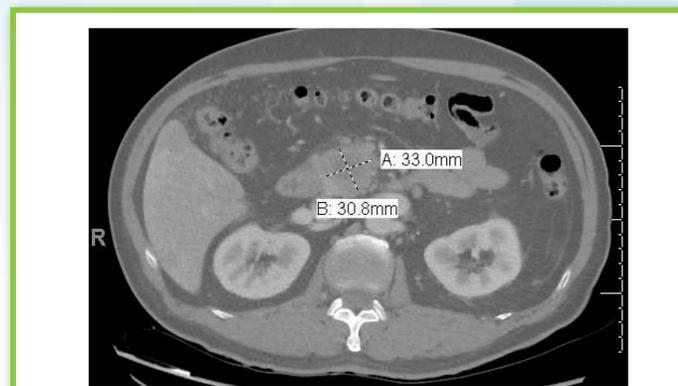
CT Abdomen/Pelvis. Pancreatic mass noted.
